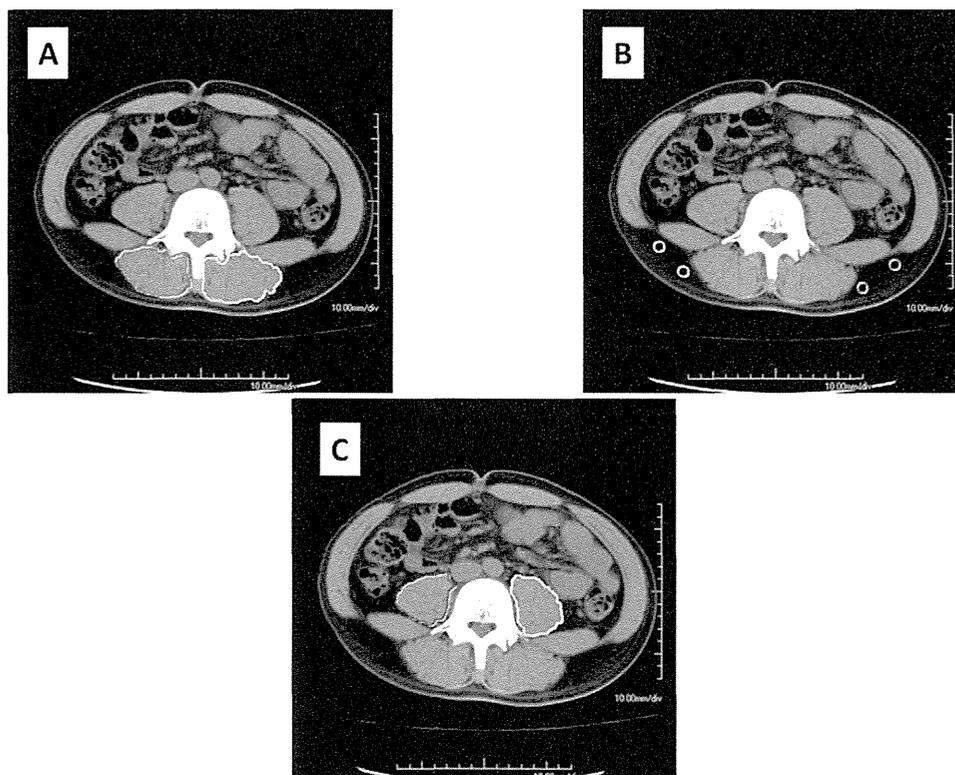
Cross-sectional CT images at the umbilical level. (A) Subfascial muscular tissue in the multifidus muscle was precisely traced. (B) Four small circles were placed on subcutaneous fat away from major vessels. ROIs of the multifidus muscle and the subcutaneous fat (Hounsfield units) were measured with the Aquarius NET server. (C) The areas of bilateral psoas muscle were measured by manual tracing.
